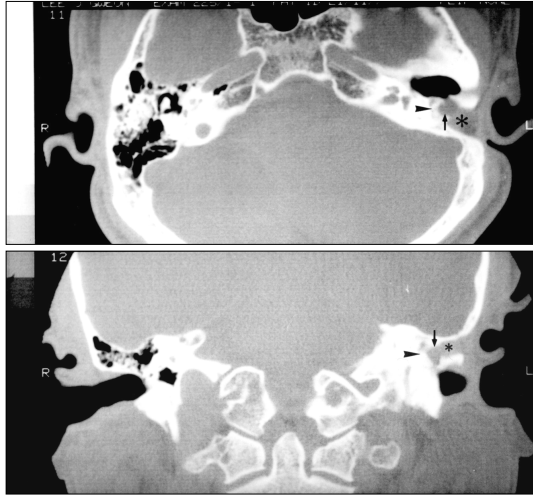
Follow-up temporal bone CT in residual mastoid cholesteatoma. Residual mastoid cholesteatoma destroyed the obliterated portion with bone paste and burst out the mastoid cavity into the tympanic cavity (arrow : residual mastoid cholesteatoma, * : inferior based flap, arrow head : this is the obliterated portion with bone paste. it was destroyed by cholesteatoma).
